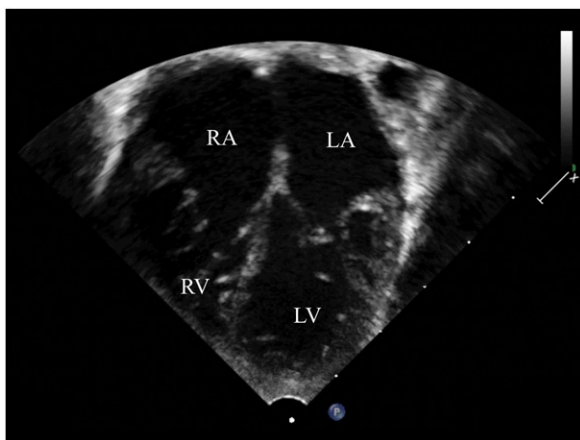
Apical 4-chamber echocardiogram demonstrating enlarged right and left atria bilaterally.
